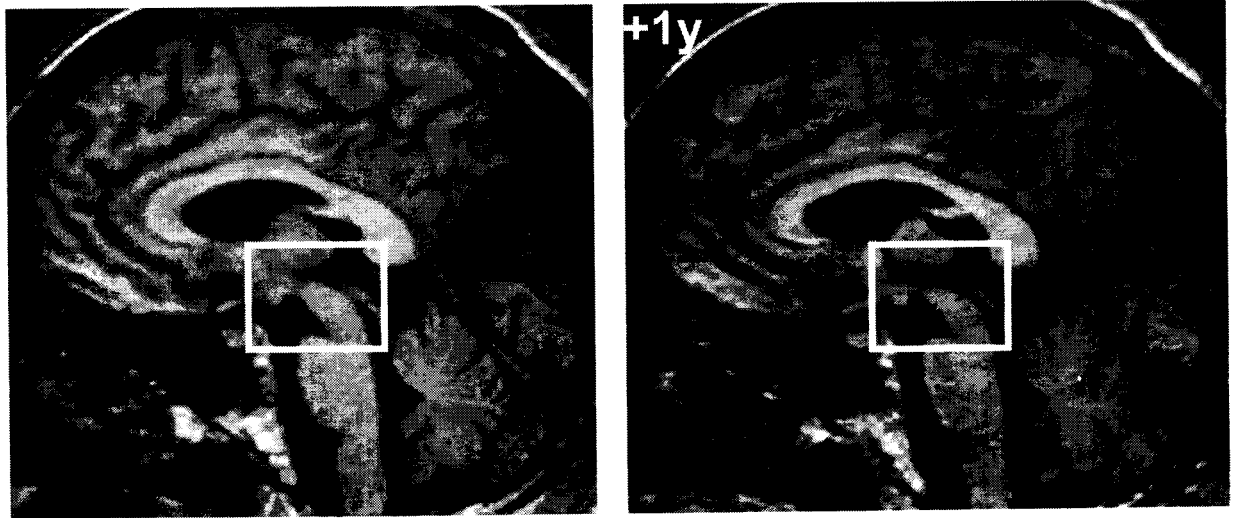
MRI brain showing selective midbrain atrophy
